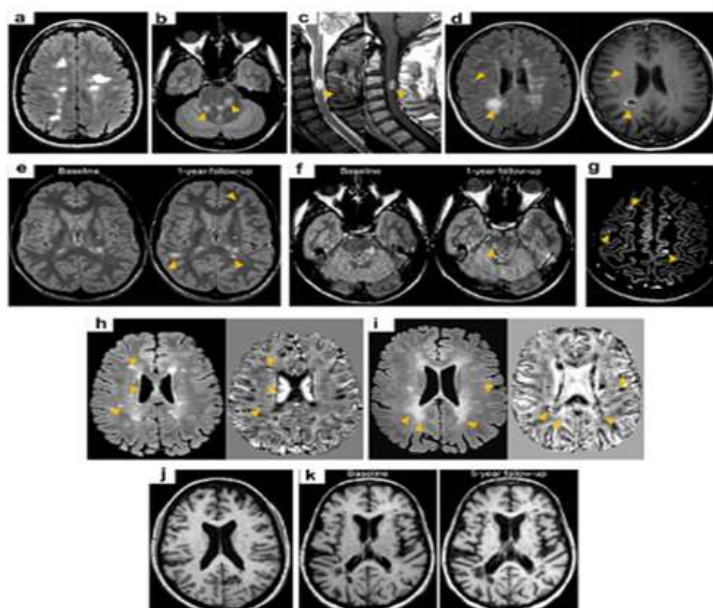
The development of multiple sclerosis into secondary progressive multiple sclerosis (SPMS) can be predicted with the aid of early MRI findings. High volumes and numbers of T2-hyperintense lesions, infratentorial and spinal cord lesions, and gadolinium-enhancing lesions at baseline are significant predictors. Disease progression is also linked to a rise in paramagnetic rim lesions, cortical lesions, central vein sign, and T2 lesion burden. Faster brain shrinkage and early brain volume reduction are additional indicators of an increased likelihood of increasing impairment..
